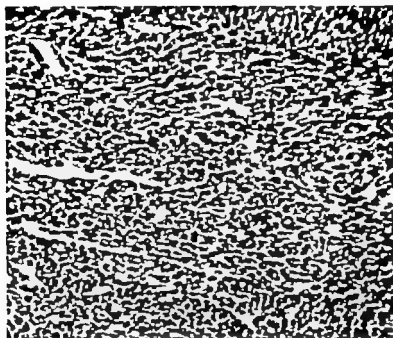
(No 41836) Cellular synovial sarcoma from the under surface of the quadriceps tendon. The lesion occurred in a boy aged 16 The roentgenogram showed a definite tumor shadow raising the tendon and the patella. The tumor was excised in 1928 but recurred, and the leg was amputated in 1929 Following this the patient could not be traced.
